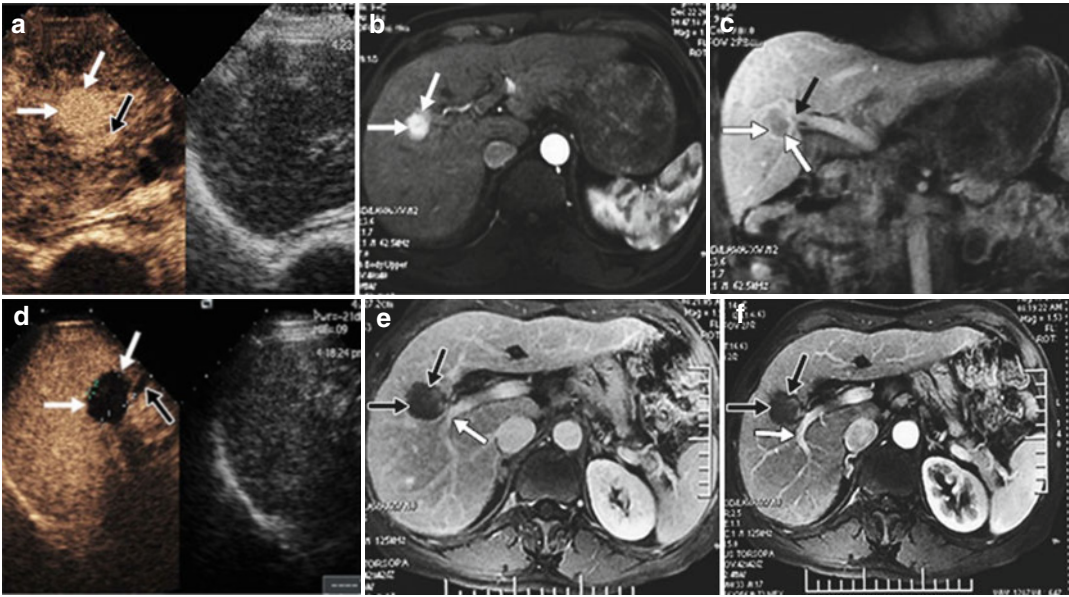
Contrast-enhanced images show a 3.3×2.3 cm HCC nodule adjacent to the right portal vein (white arrows in e and f) in the liver of a 63-year-old man treated with MWA. (a) Preoperative contrast-enhanced ultrasound (CEUS) and (b) transverse and (c) coronal preoperative MRI show that there is one HCC nodule (white arrows) with hyperenhancement during the arterial phase of CEUS, with high signal during the arterial phase of MRI and with low signal during the portal phase of MRI. The
